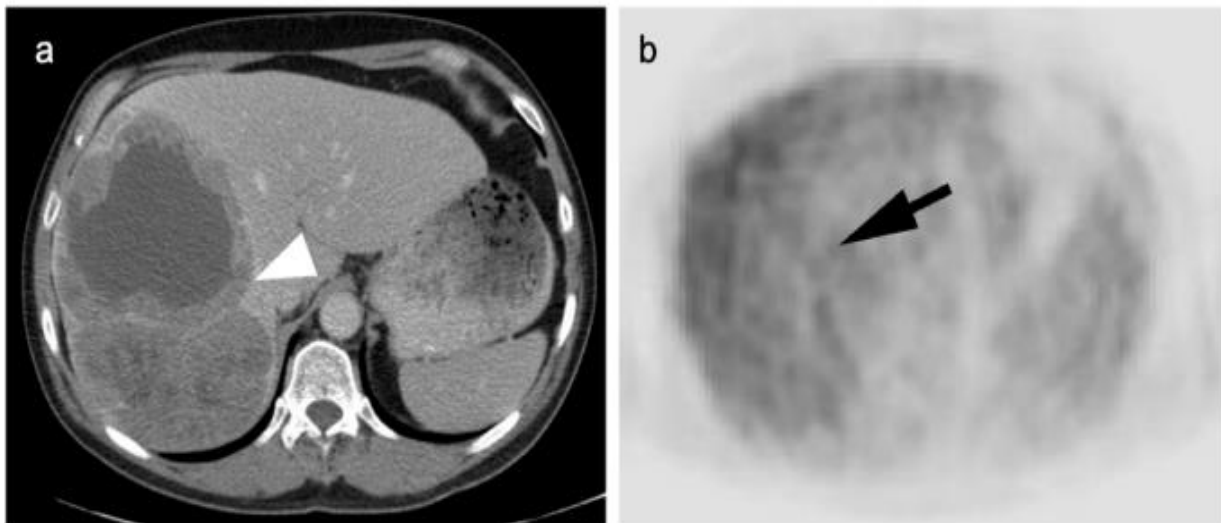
Metastatic gastric cancer (a) Axial FDG PET-CT and (b) MIP image. Markedly hypermetabolic in gastric carcinoma (white arrow) with widespread hepatic metastases (white arrowheads) [9]
